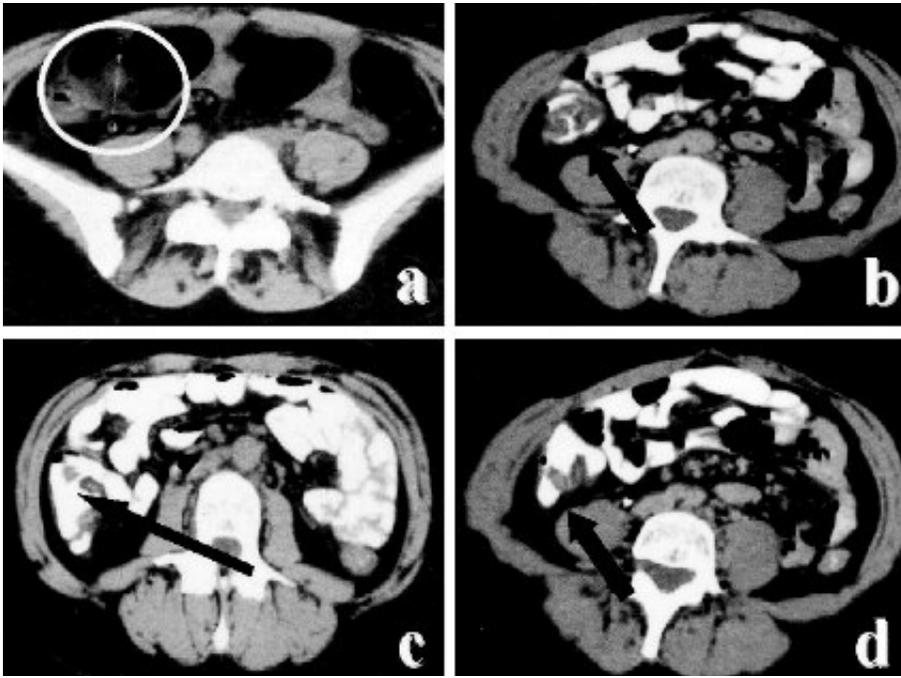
a) Abdominal-pelvic CT scan without luminal contrast means. The caecum shows protrusion of a vegetating mass with clear margins. An intestinal tract on the external part of the caecum shows thick edematous walls; b) abdominal-pelvic CT scan with barium. The caecum shows an endoluminal "body" with smooth surfaces; c) Abdominal-pelvic CT scan with barium. The caecum filling defect is in turn site of barium passage; d) protrusion of the valve in caecal lumen.
